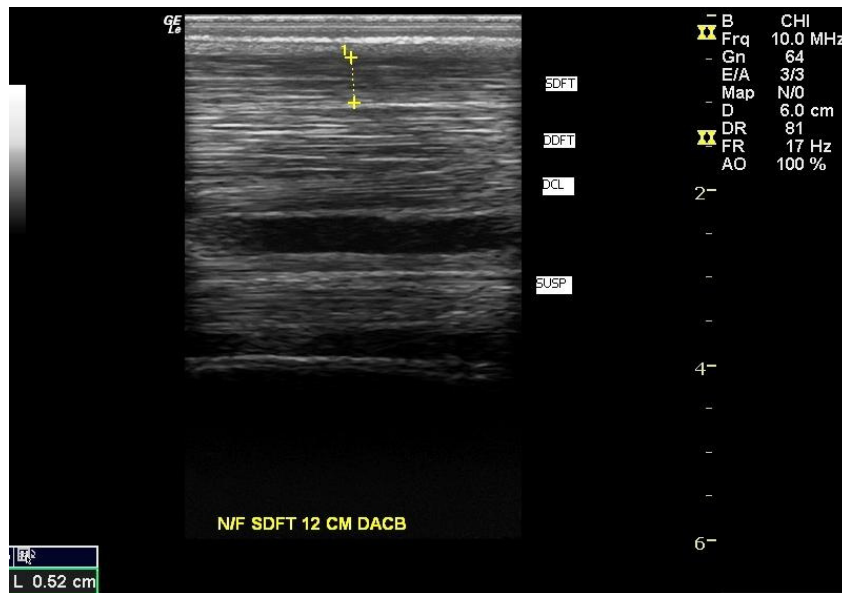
Normal ultrasound anatomy of the tendons at the back of the cannon. The tendon fibres are aligned along the direction of force from proximal (LHS of screen) to distal (RHS of screen). SDFT = superficial digital flexor, DDFT = deep digital flexor tendon, DCL = distal check ligament, SUSP = suspensory ligament.
